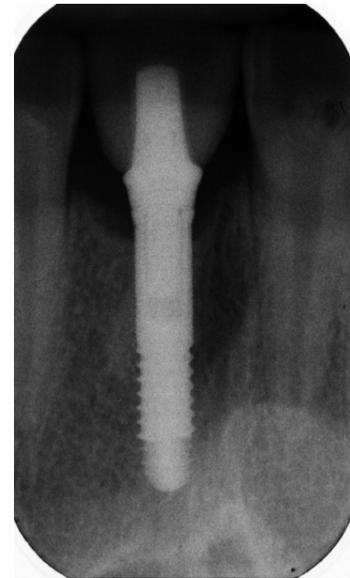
Post-operative clinical radiograph, taken 6 months after allograft placement showing higher bone levels in comparison with what was observed before treatment.
